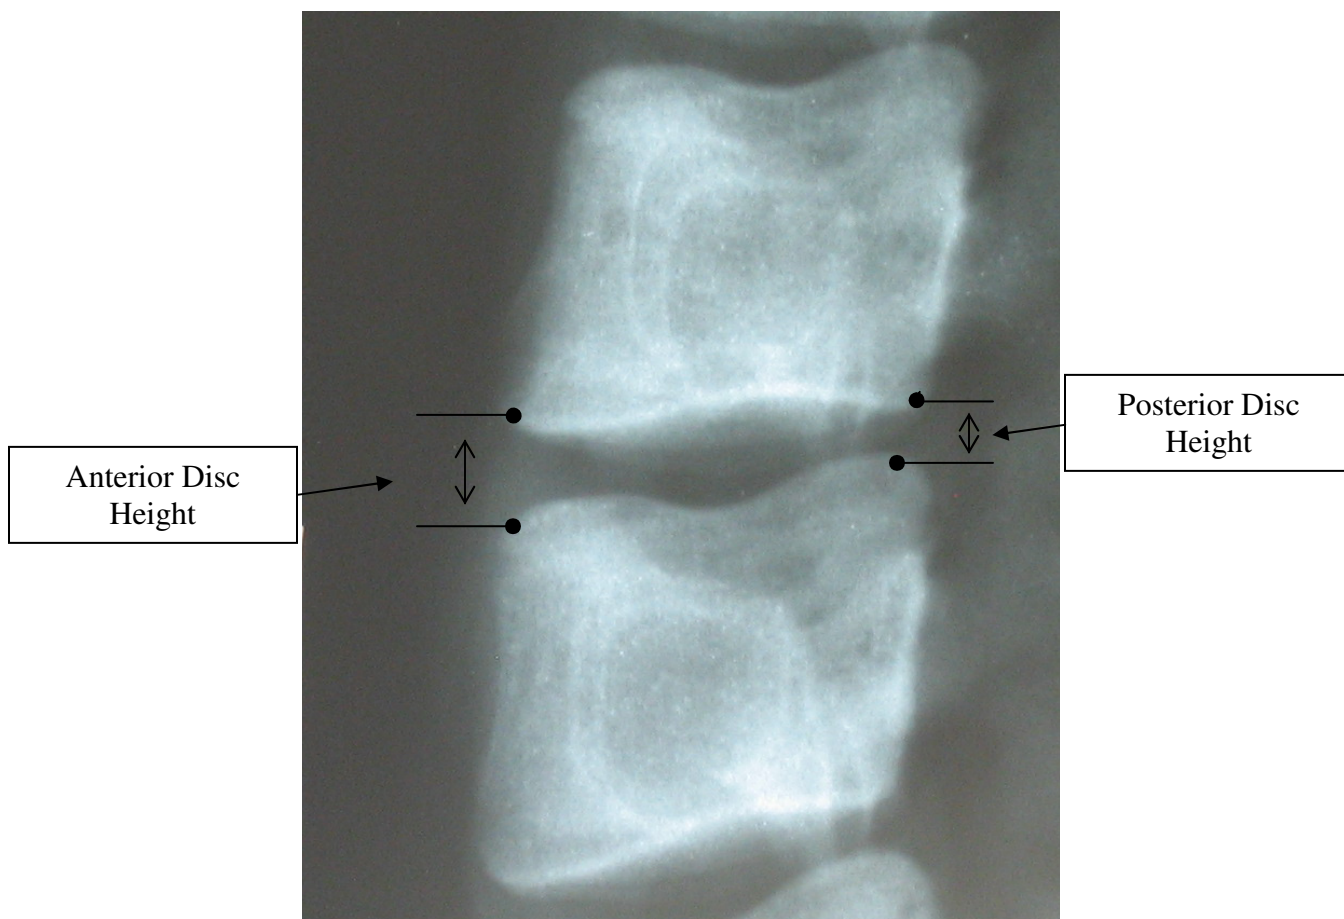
Farfan et al (1973) defined disc height as the mean of the distance between ventral edges and the dorsal edges of the superior and inferior vertebrae. The edges of the vertebral bodies are identified as the points that are furthest from the center of the vertebral body. Disc height was expressed in units of disc depth to allow for radiographic distortion.
